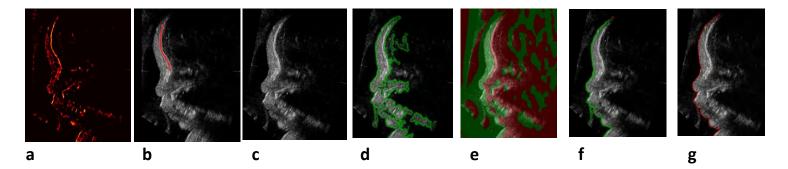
Segmentation of the mid-line fetal profile from a single slice of a 3D ultrasound volume
